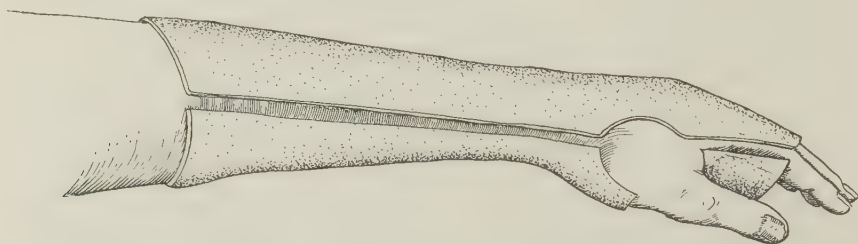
COMMON FRACTURE OF LOWER END OF RADIUS TREATED IN A SIMPLE PLASTER-OF-PARIS CASE WHICH HAS BEEN BISECTED TO PERMIT INSPECTION AND REMOVAL.
